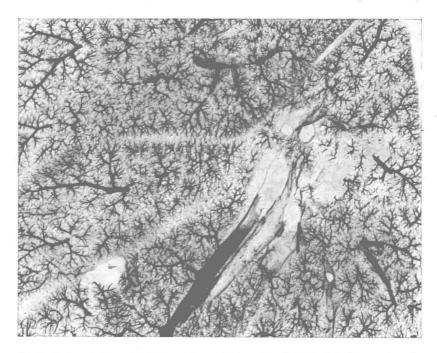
Photographic print from radiograph of a thin slab of adult human lung in which pulmonary arteries were injected with a radio-opaque substance. This demonstrates clearly the characteristic branching pattern of pulmonary arteries and arterioles within pulmonary lobules (from a radiograph provided by Dr. Daniel Jenkins, Baylor School of Medicine, Houston, Texas).
